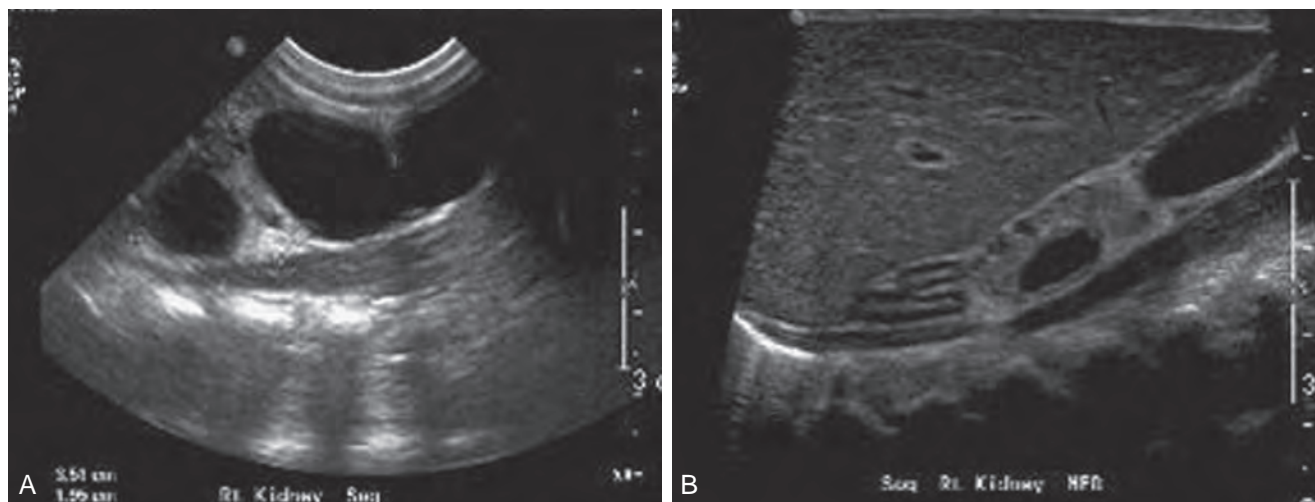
A, Prevesicostomy ultrasonography of the right kidney demonstrating massive hydronephrosis with echogenic parenchyma. B, Postvesicostomy ultrasonography demonstrating a decompressed kidney with echogenic parenchyma and cortical cysts. (Courtesy C. Peters.)
